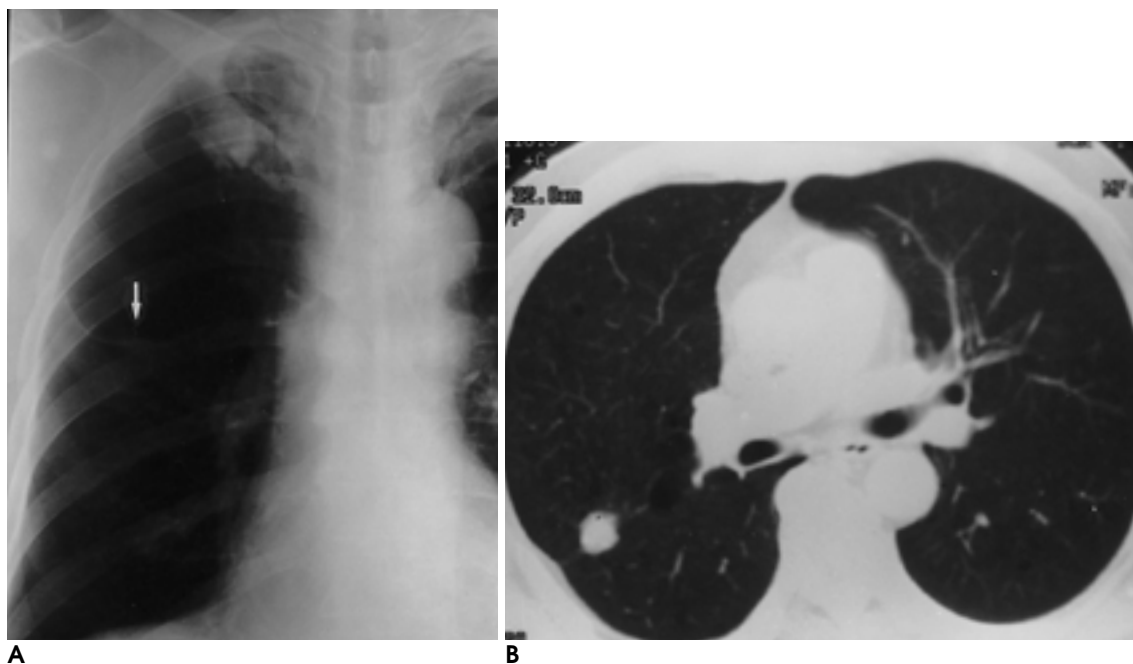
Frontal plain chest radiograph (A) of a 57-year-old male patient with chest pain shows sequelae of pulmonary tuberculosis on the right upper lobe and a nodular lesion (arrow) on middle lung zone combined with thickening of minor fissure that was initially considered as a sequelae of pulmonary tuberculosis. Sputum cytology revealed positive for malignancy. CT scan with lung windows (B) shows a 2 cm subpleural nodule on the right middle lobe that abutted the minor fissure. Bronchoscopy was not performed in this patient. Surgical stage was T1N0M0 and the cell type of the tumor was large cell carcinoma.
